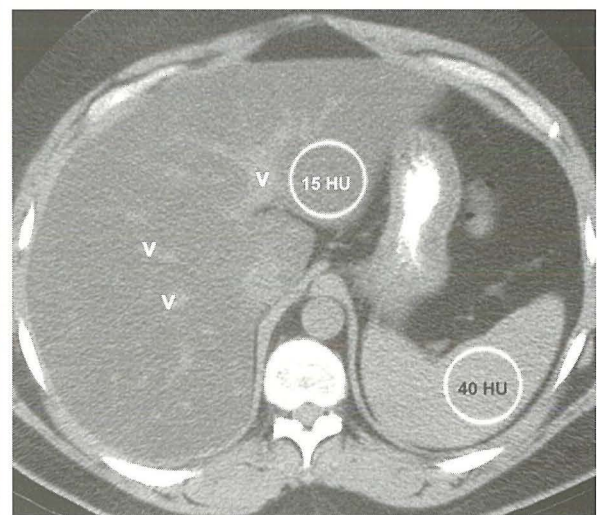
With diffuse fat accumulation in the liver at un-enhanced CT, the density of the liver (15 HU) is lower than that of the spleen (40 HU) and intrahepatic vessels (v) appear hyperdense in comparison with the liver.
